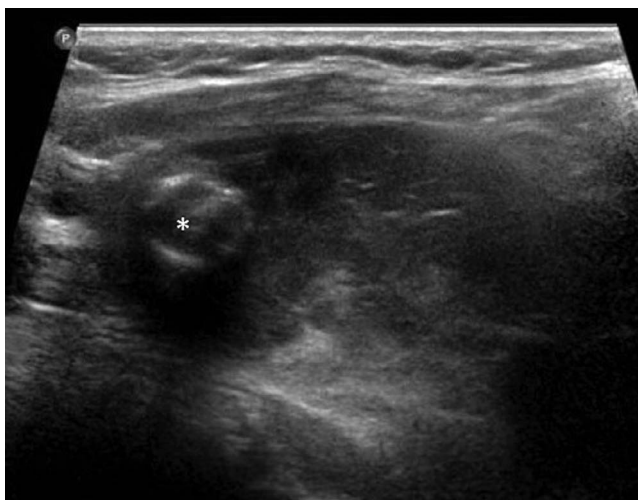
Thyroid ultrasound in vertical axis shows a 1.1-cm nodule (asterisk) with coarse calcification identified within the superior aspect of the right lobe.
